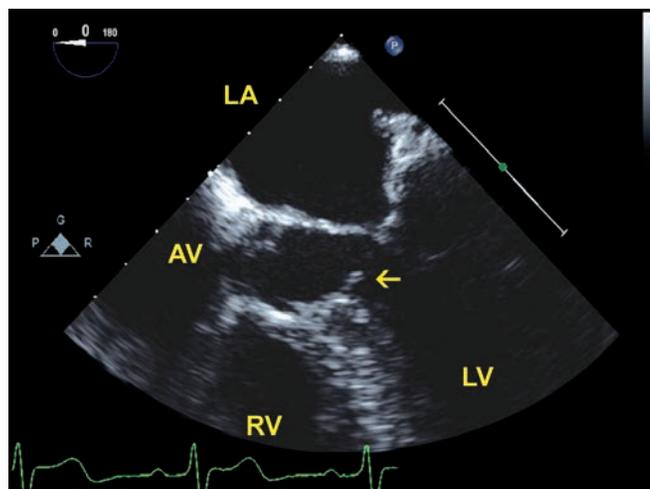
Transesophageal echocardiography showing the subaortic membrane (arrow) arising from the interventricular septum just proximal to the junction of the aortic root with the septum.
